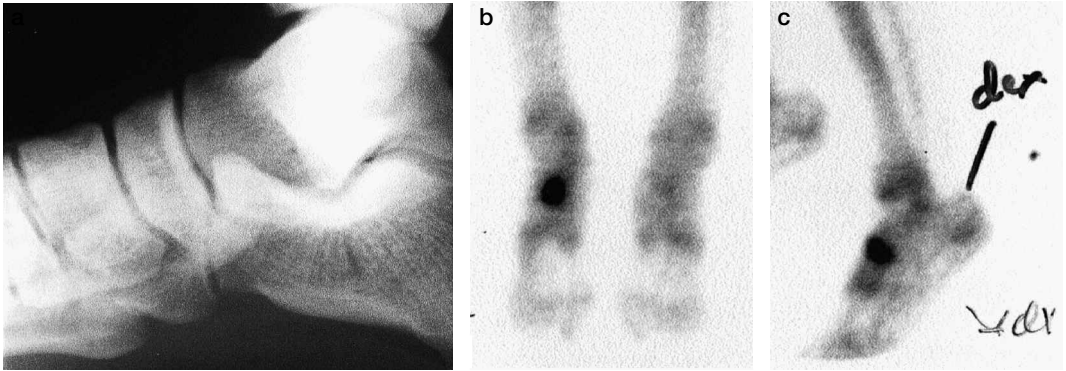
A 20-year-old male high-jumper who had to give up jumping because of ankle pain during exercise. The radiograph remained negative (a). Scintigraphy showed a bone stress injury in the navicular bone (b-c).
